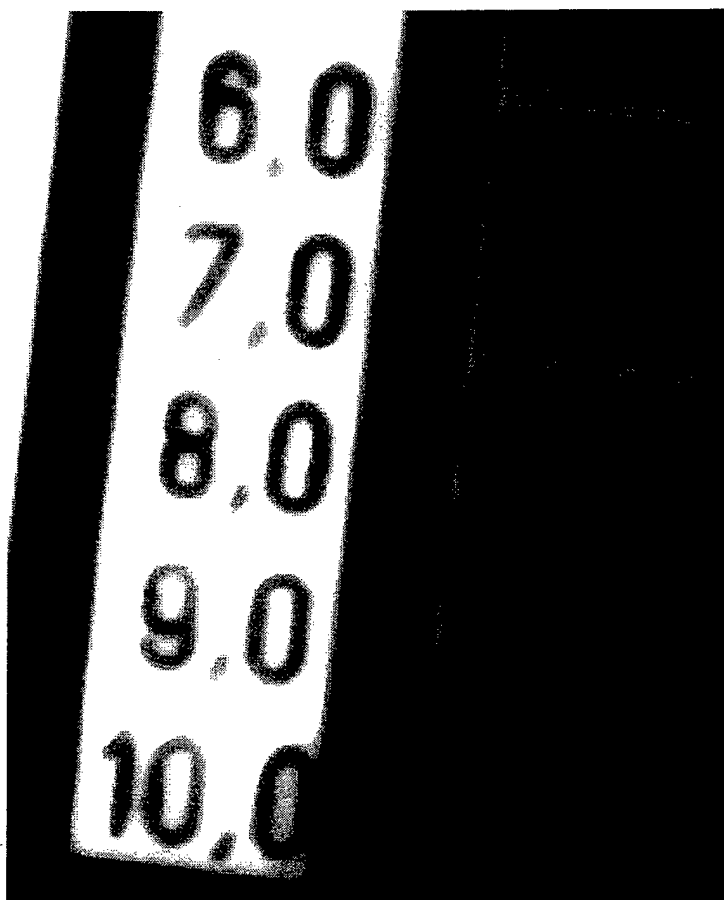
X-ray of resolution pattern using Eu doped Y₂O₂S phosphor screen (red). Numbers represent resolution in line pairs/mm. Note that 8 lp/mm is visible.
